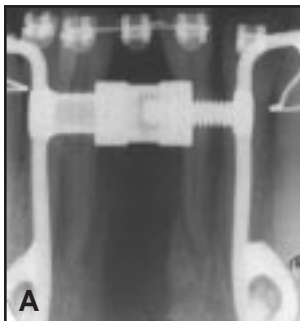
Progressive periapical x-rays taken on 23-year-old male. A. Two weeks after distraction. B. Five weeks after distraction. C. Nine weeks after distraction. D. Twelve weeks after distraction.
